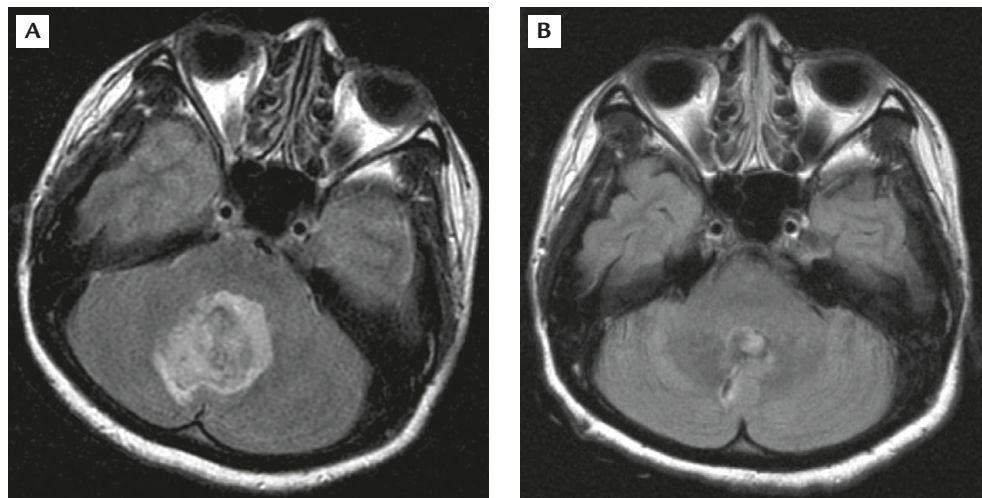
Cerebellar hemorrhage with brainstem compression in a 35-year-old pregnant woman. T2 fluid-attenuated inversion recovery magnetic resonance imaging (A) before removal of a hematoma and (B) after removal of hematoma show a substantial improvement of compression.
